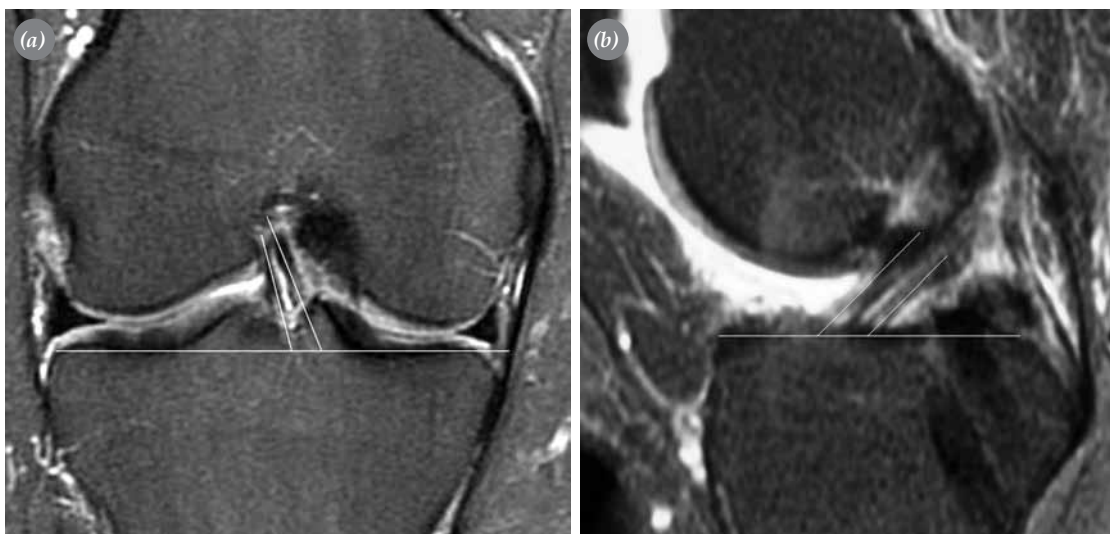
The angular relationship between the two bundles and the tibial plateau on (a) sagittal and (b) coronal T2-weighted images.
